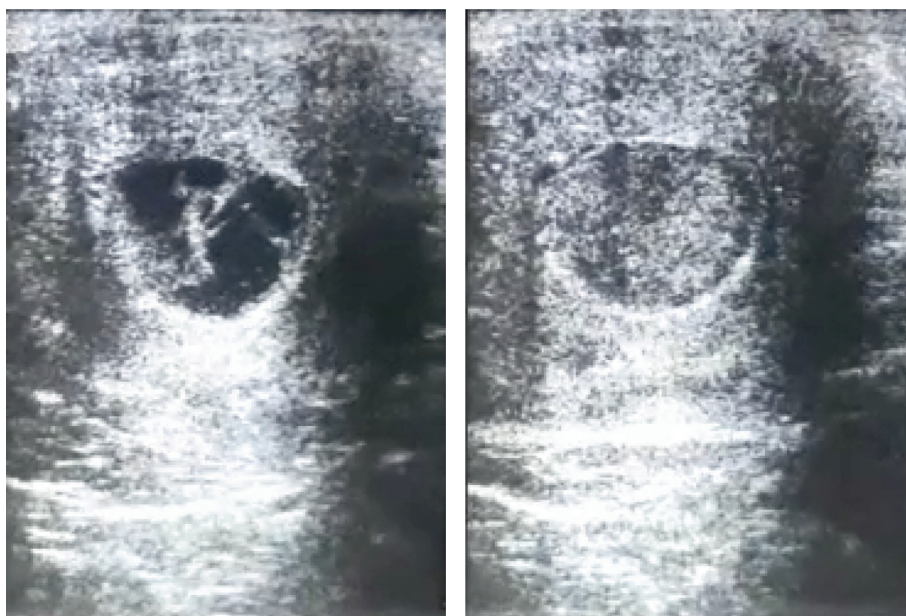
Transrectal ultrasonographic images of left ovary of Case 1 10 months later. (A) Ultrasonography shows an enlarged left ovary (9.9 cm) and two well defined structures (4.28 cm), enclosed by a hyperechoic wall (arrow), surrounded by heterogenous ovarian stroma, a fibrous aspect (3 cm) and (B) containing focal hyperechoic areas (arrowhead) encircled by echogenic and homogenous content.
